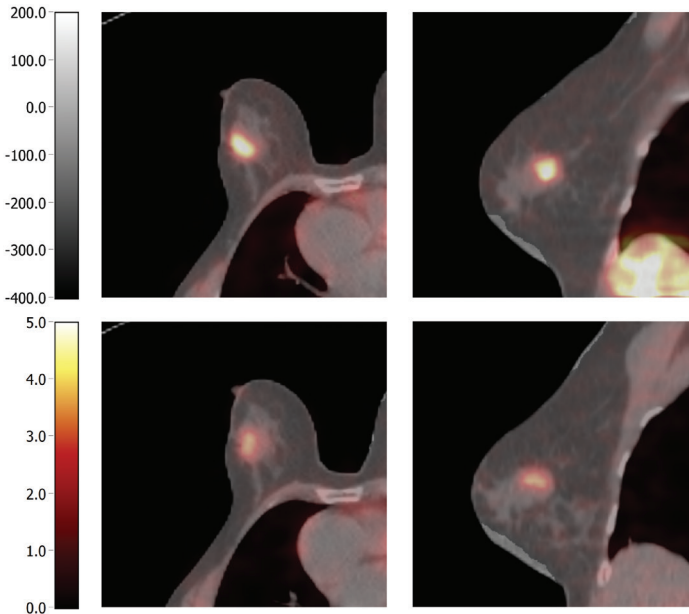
Transversal (left) and sagittal (right) fused SPECT/CT images show focal MIBI uptake corresponding to a primary invasive ductal carcinoma located in the upper outer quadrant of the right breast. Top row: early acquisition after 5 min p.i. Bottom row: delayed acquisition after 90 min p.i. SPECT images were reconstructed with 9 iterations of Evolution. Colour bars are expressed in Hounsfield units (CT) and SUV (g/mL, SPECT).
